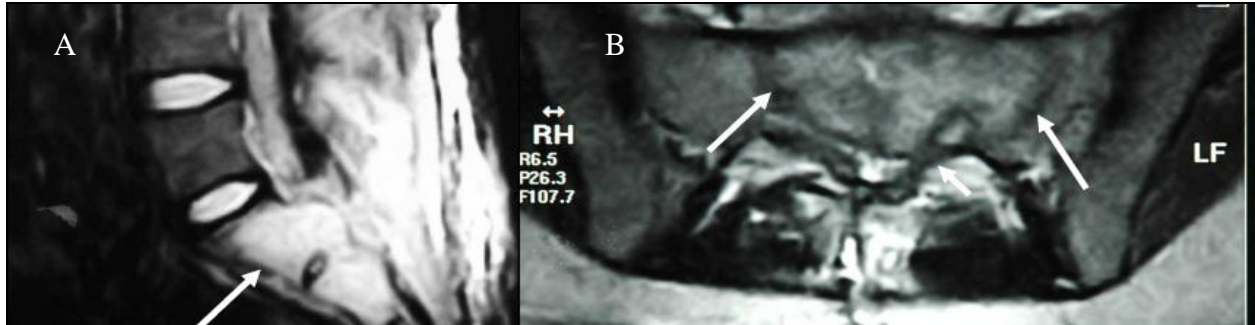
(A, B) Images from MRI scan performed post-S1 laminectomy, sagittal (A) and axial (B) views, demonstrating tumour extension into the neural canal (arrows) adjacent S1 and S2 segment
